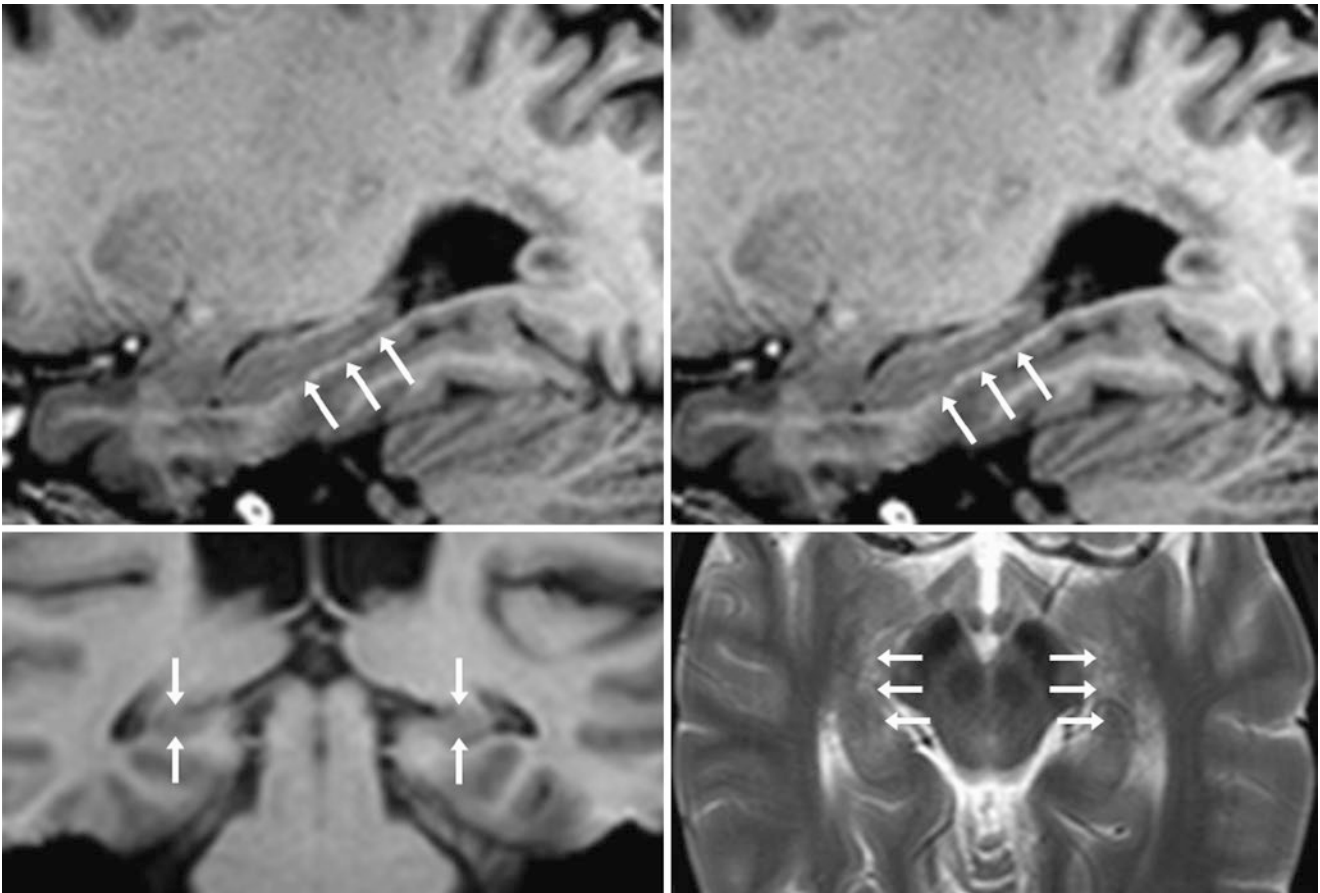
A 58 year old whose images showed a relatively uniform and smooth but slightly corrugated appearance of the hippocampi bilaterally (*arrows*) on a 3 T MRI with thin (1-mm thickness) sagittal T1WI
